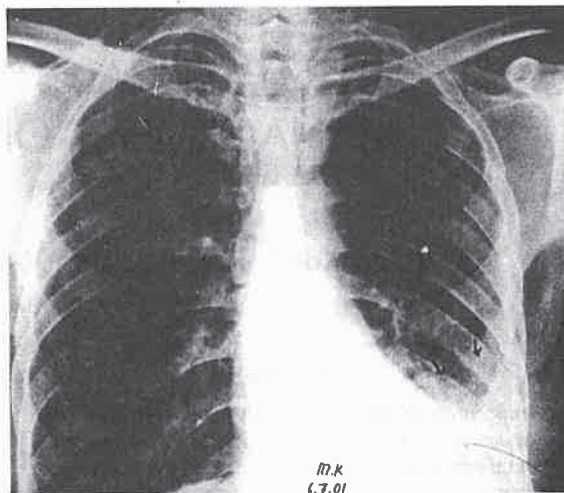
Chest roentgenogram showing pleural empyema
